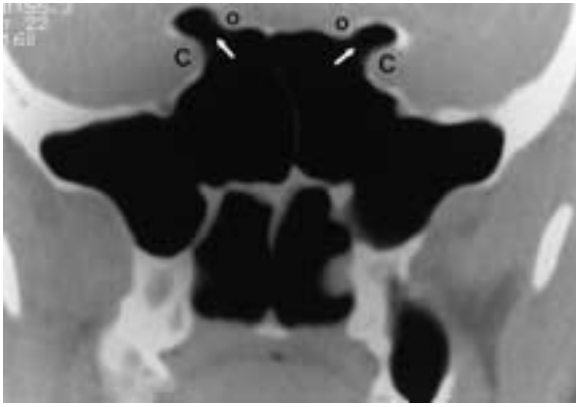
Extensive pneumatization of the sphenoid sinus. Coronal CT image shows pneumatization of both anterior clinoid processes (arrows) and their relationship to the optic nerves (o) and internal carotid arteries (C). The presence of anterior clinoid pneumatization is an important indicator of optic nerve vulnerability during FESS.
